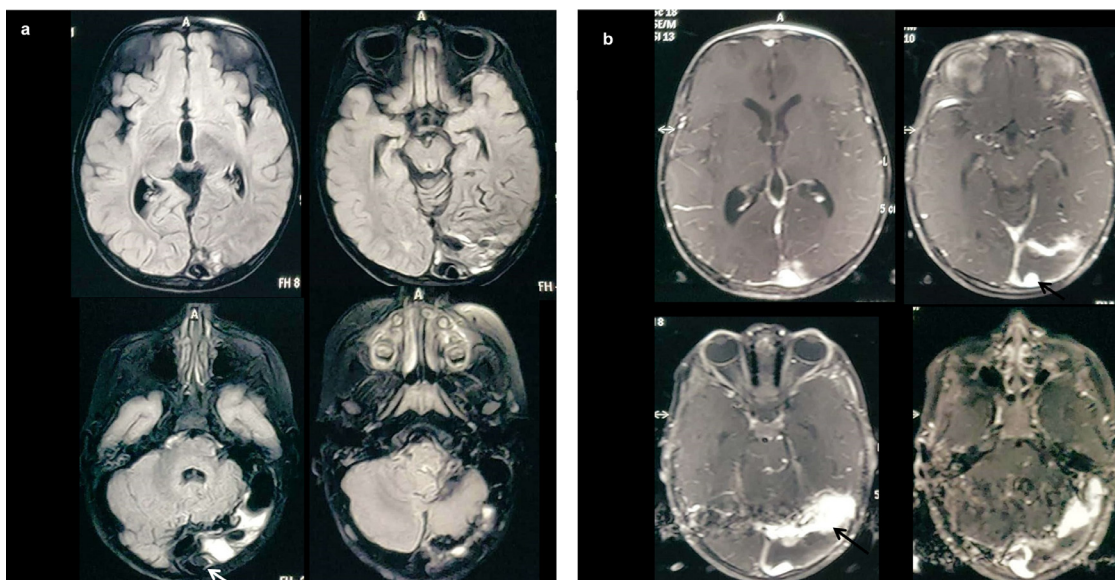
Contrast-enhanced MRI brain of the patient at 3 years of age. (a) Axial FLAIR images show areas of abnormal signal intensities (white arrow) within dilated left transverse sinus, sigmoid sinus, and superior sagittal sinus. (b) On postcontrast images, partial patency of left transverse and sigmoid sinus is seen (black arrow).
